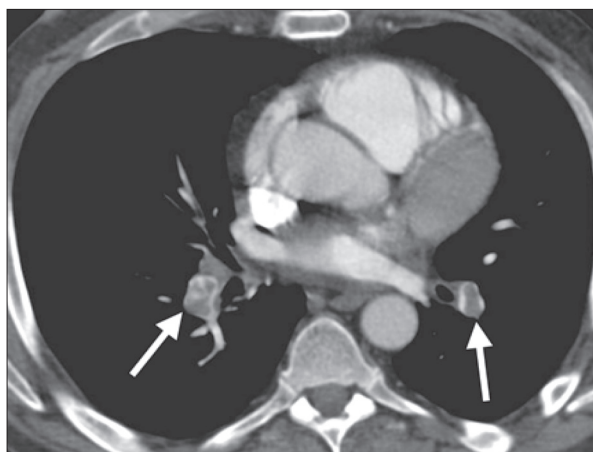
CT – pulmoangiography.
